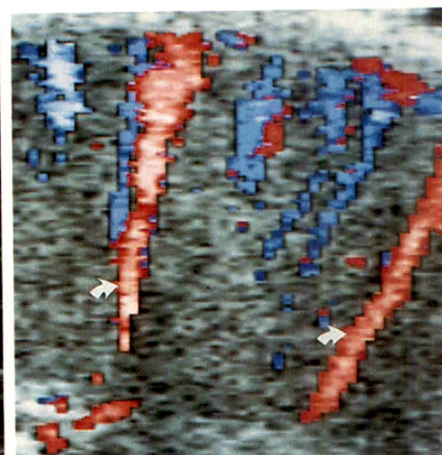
Doppler images of intratesticular arteries.
